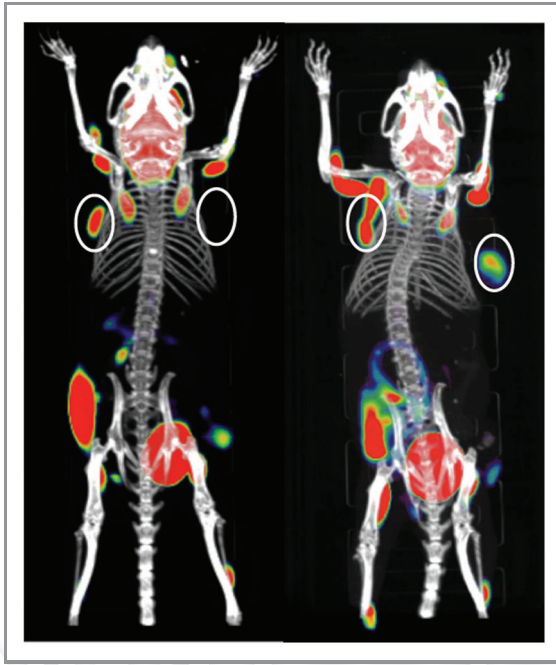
MART-1 specific CTL limit and clear growth of matched melanoma tumors. In vivo PET imaging was performed to assess the levels of FDG uptake by the M202 and M207 tumors. The circles indicate the location of the M202 (right) and M207 (left) tumors.
